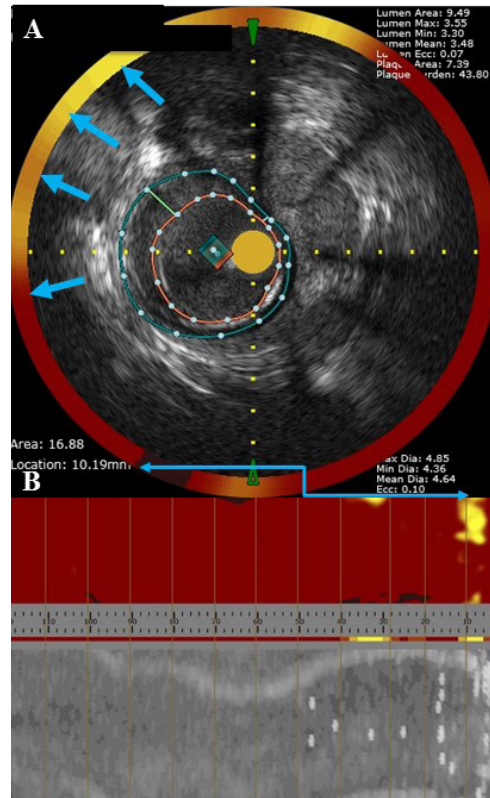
NIRS-IVUS: Chemogram with Intravascular Ultrasound
